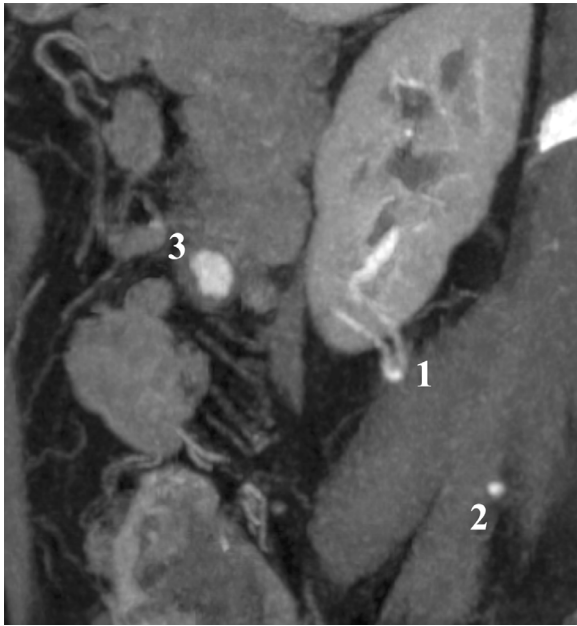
The contrast-enhanced computed tomography (CECT) oblique maximum intensity projection (MIP) reconstructed sagittal image. The 3 sources (1, 2, and 3) of bleeding are identified in the same cross section.
